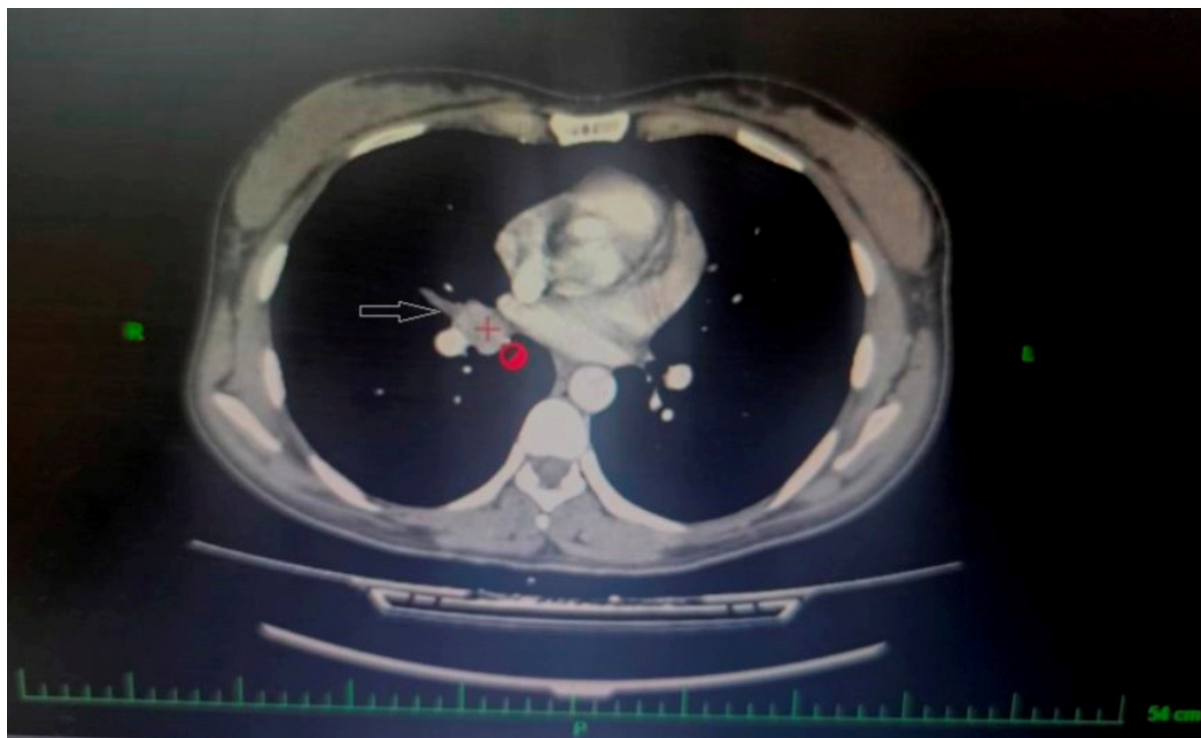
Contrast-enhanced computed tomography (CT) of the chest demonstrated a 25 × 15 mm enhancing endobronchial mass in the right bronchus intermedius, causing partial airway obstruction and right middle lobe (RML) collapse. Right lower lobe (RLL) ground-glass opacities (GGOs) were suggestive of aspiration
